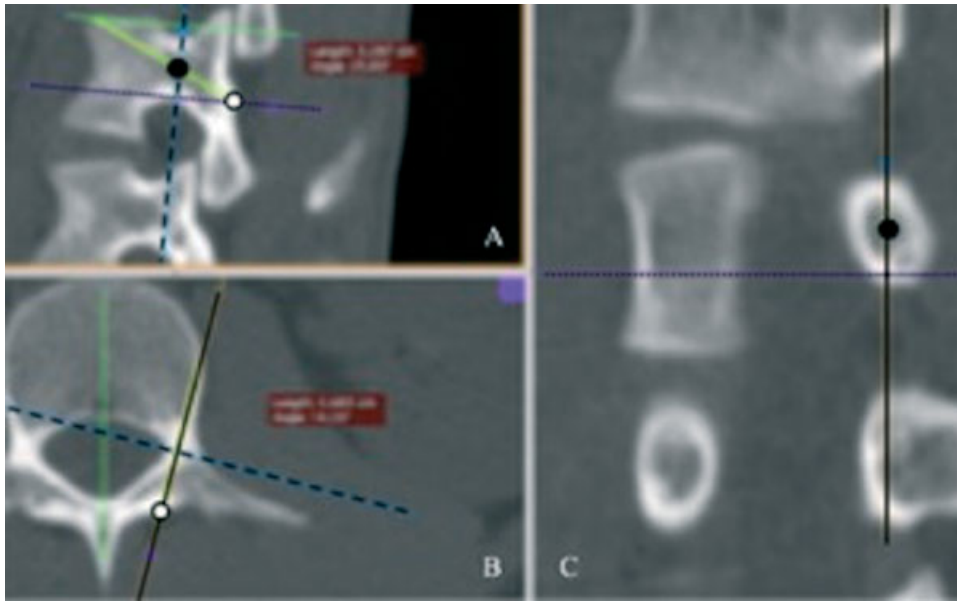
Sagittal (A), axial (B), and coronal (C) computed tomography images evaluating the length of the trajectory of the cortical screw and the cranial angle.
